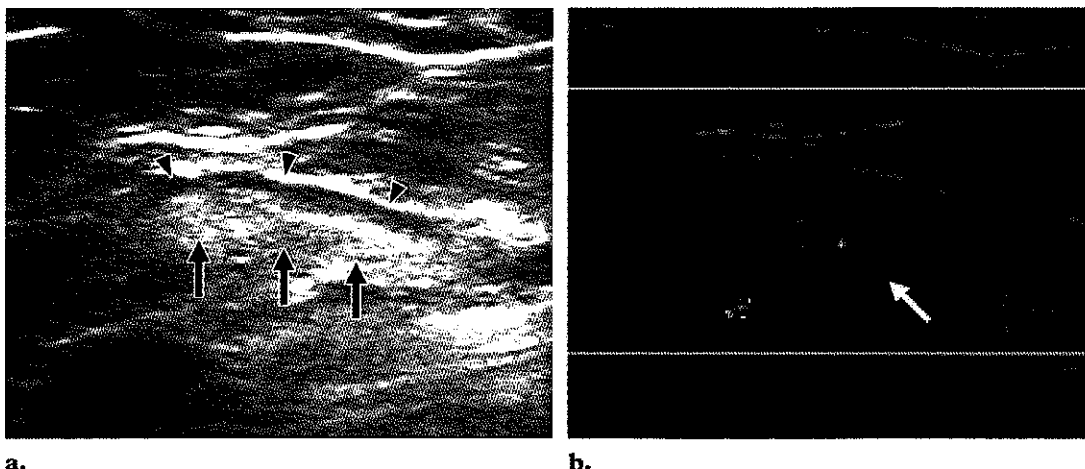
(a) US image shows a normal lymph node with a thin cortex (arrowheads) and a large fatty hilum (arrows). (b) Color Doppler US image shows normal bidirectional hilar blood flow (arrow).
